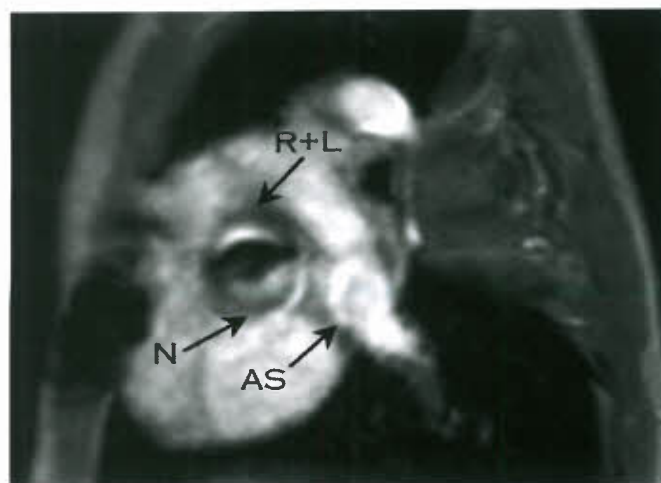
MRI image of bicuspid aortic valve. Although a raphe is not visualized, there is fusion of the right and left coronary cusps (R+L). N, noncoronary cusp; AS, atrial septum. (Courtesy of E.S. Rivera and T. Geva.)
